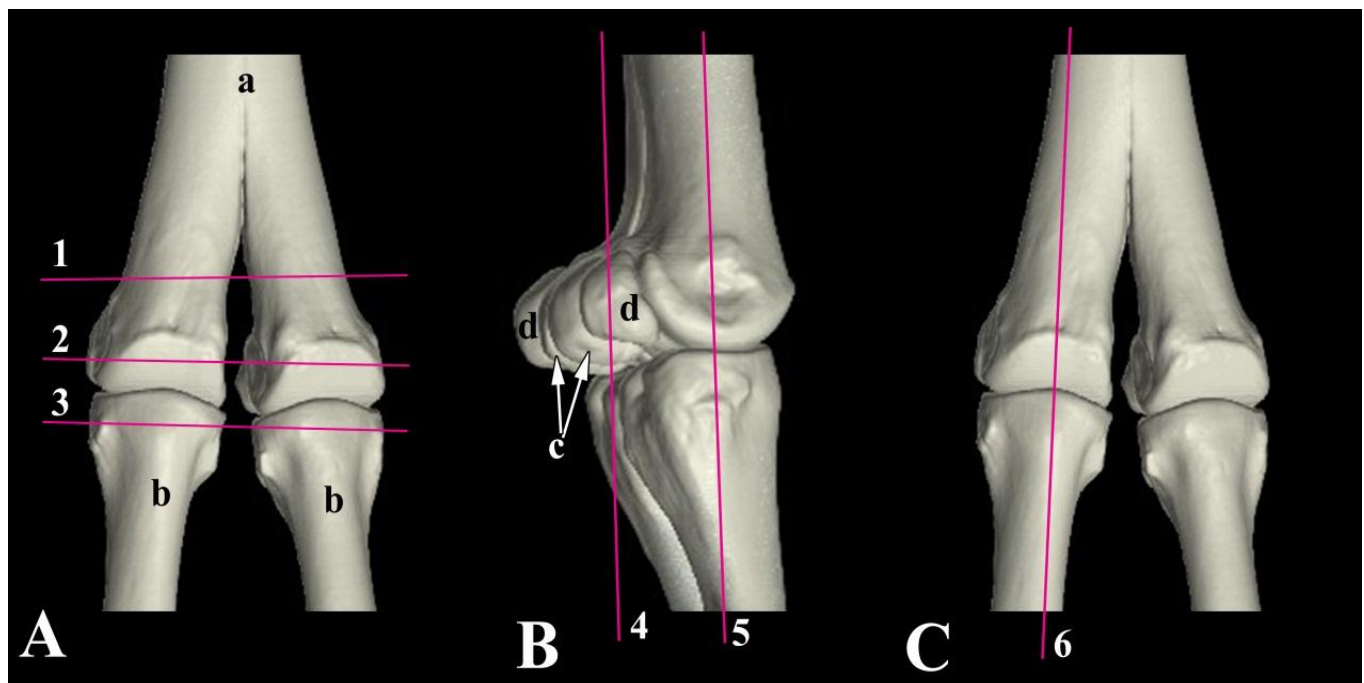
Three dimensional reconstructed computed tomographic views of fetlock joint of camel. Numbered planes indicated the approximate levels of cross anatomical sections and their corresponding magnetic resonance imaging and computed tomographic depictions: A- Dorsal view showing the selected planes for transverse sections (1-3); B- Lateral view showing the selected planes for dorsal sections (4, 5); C- Dorsal view showing the selected planes of sagittal sections (6); a- Metacarpus/metatarsus; b- First phalanx; c- Axial sesamoid bones; d- Abaxial sesamoid bones.
